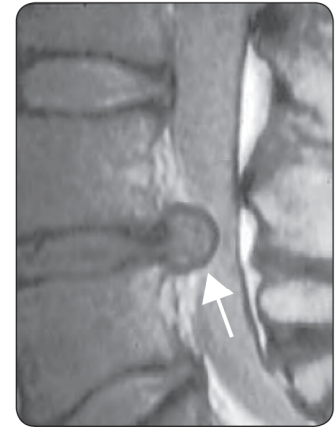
T2-weighted MRI of lumbar disc herniation
